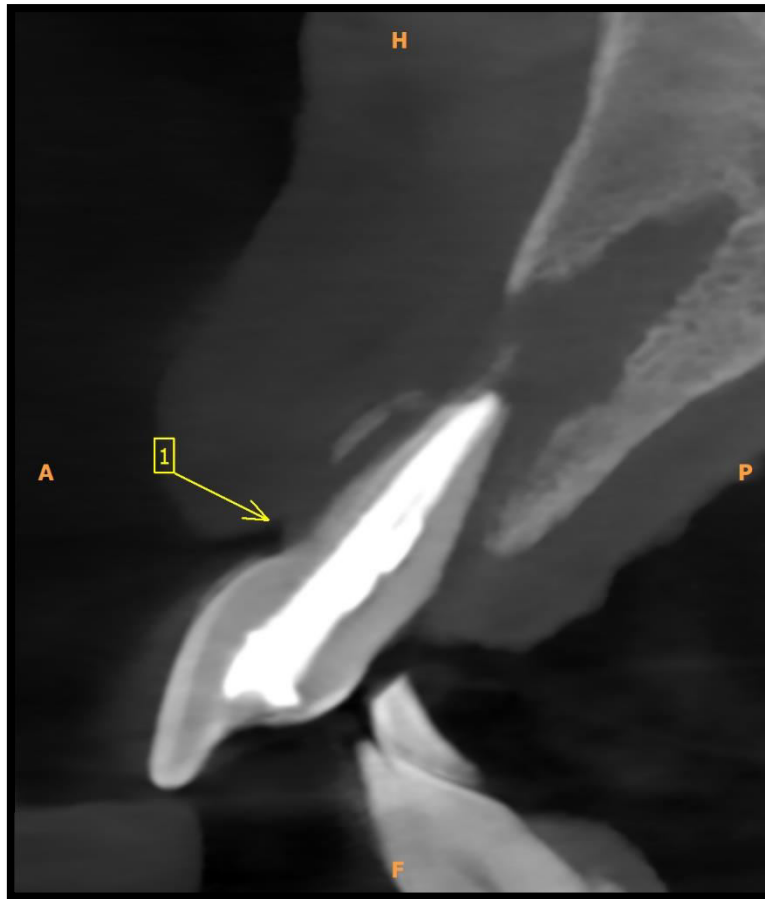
CBCT scan showing buccal cortical bone loss along with tooth moved from socket & held by soft tissue surrounding.
